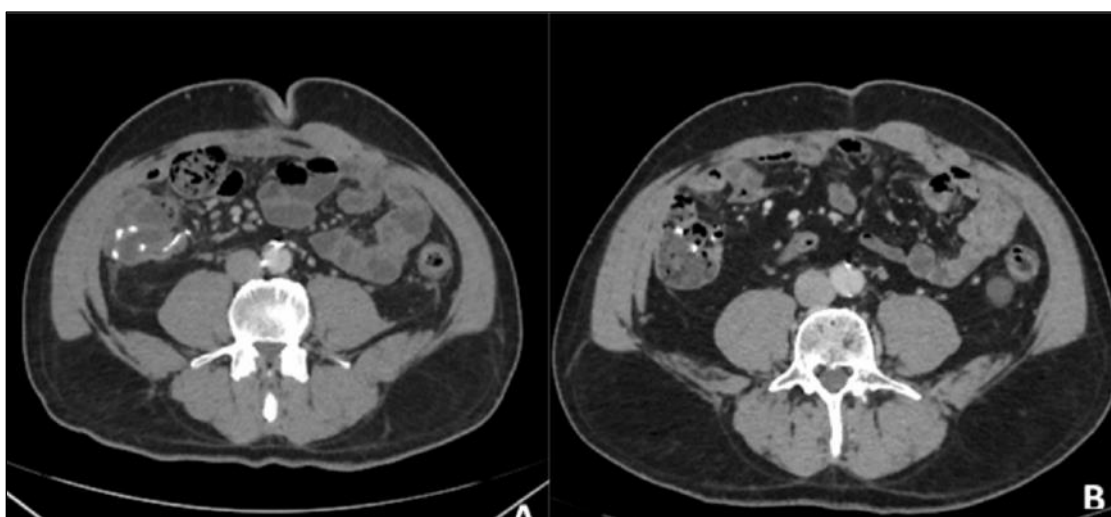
Axial CT images obtained at 3 months (A) and 6 months (B) postoperatively, showing no residual lesion or postoperative complications.
